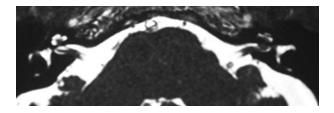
Axial, T2-weighted magnetic resonance imaging scan of the internal auditory canals, showing a rounded, isointense nodule at the fundus of the left internal auditory canal, with cochlear extension.
